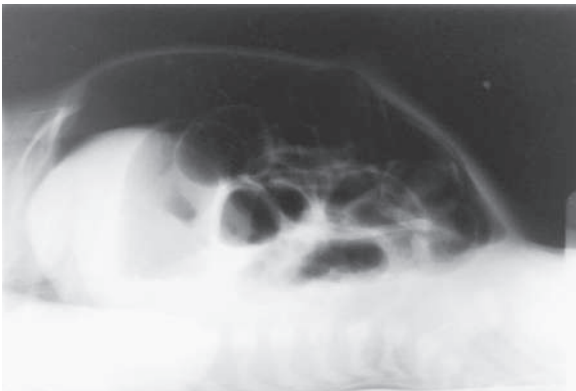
Intestinal perforation. Cross-table abdominal radiograph in patient with neonatal necrotizing enterocolitis demonstrates marked distention and massive pneumoperitoneum, as evidenced by the free air below the anterior abdominal wall.
